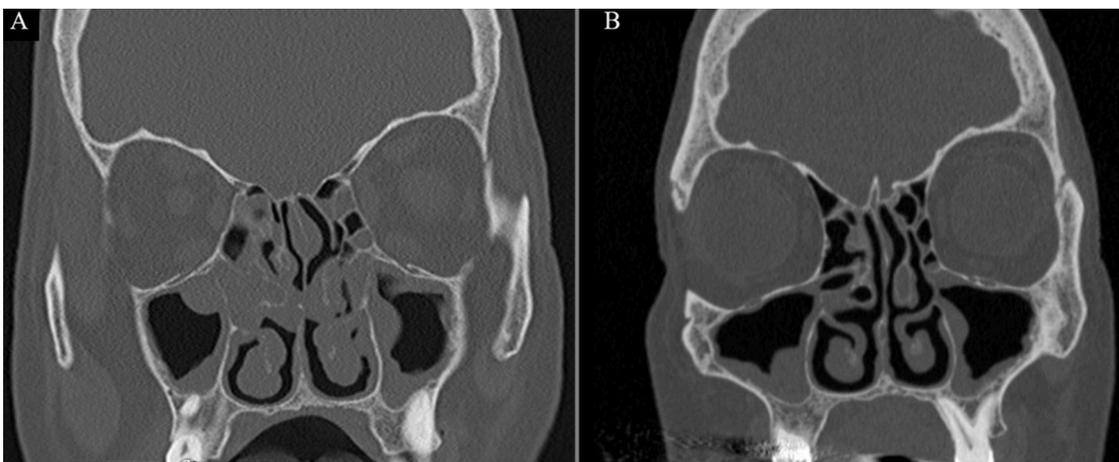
Coronal CT scan of a patients at T0 (A) and T2 (B) showing a marked improvement in the maxillary sinuses, anterior ethmoid and nasal cavities at T2 compared to T0.
